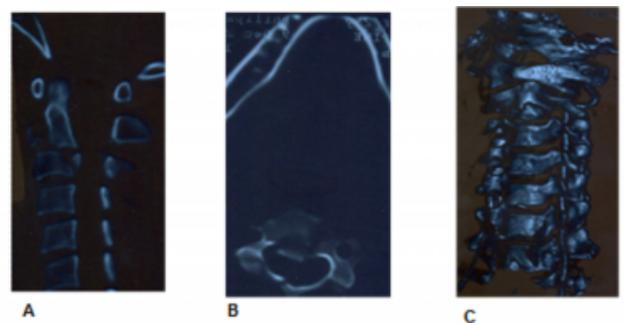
Axial CT SCAN shows teardrop fracture of the axis and burst fracture of C3 (A). Transverse CT section shows 'hemi-vertebral' fracture of C3 plus fracture of transverse foramen (B). 3D-reconstruction of CT angiography shows complete blockage of the right vertebral artery blood flow (C).
